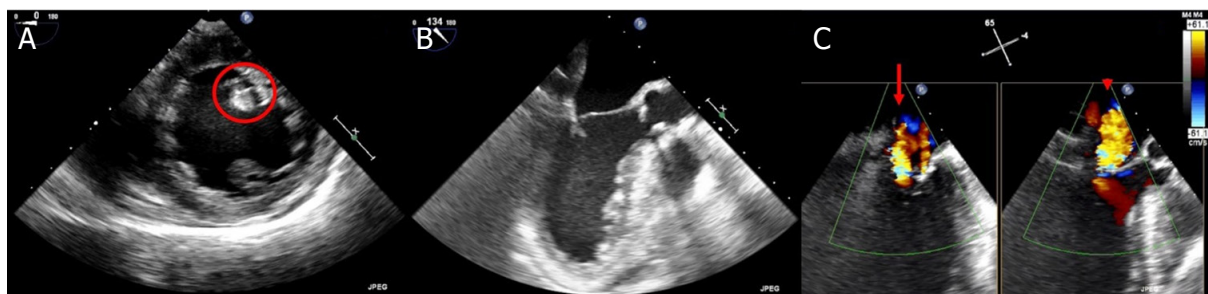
Baseline trans-esophageal echocardiogram showing partial postero-medial papillary muscle rupture (A, circle), extreme tethering of posterior leaflet with pseudoprolapse of anterior leaflet (B) and wide eccentric jet of severe mitral regurgitation mainly originating from A3-P3 (C, arrow) and extended to the medial section of A2-P2 (C, arrowhead)
